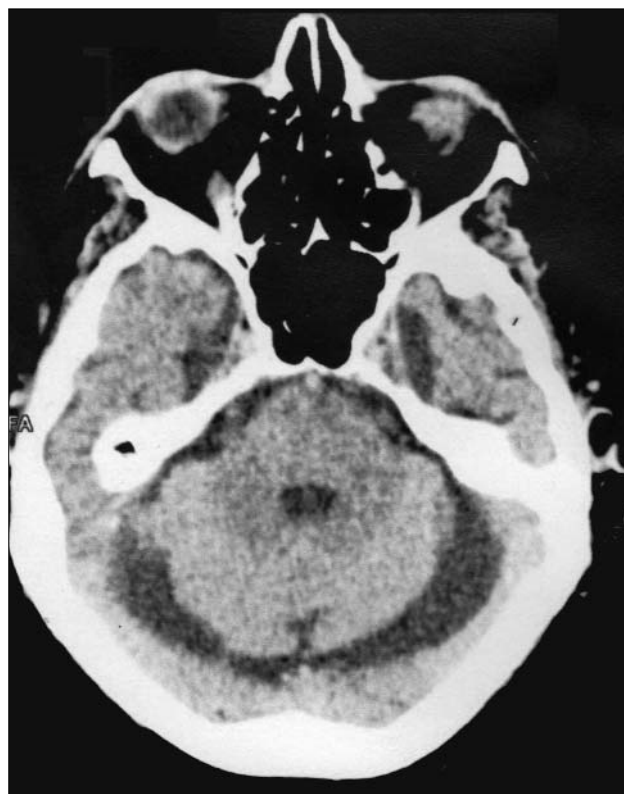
CT image – axial
